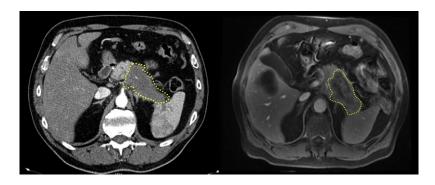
CT and MRI Demonstrate Hypoperfusion of Pancreatic Cancer Hypoperfusion of pancreatic cancer on computer tomography (left) and on magnetic resonance image (right) as evidenced by less contrast material in the tumor (note circled areas).
